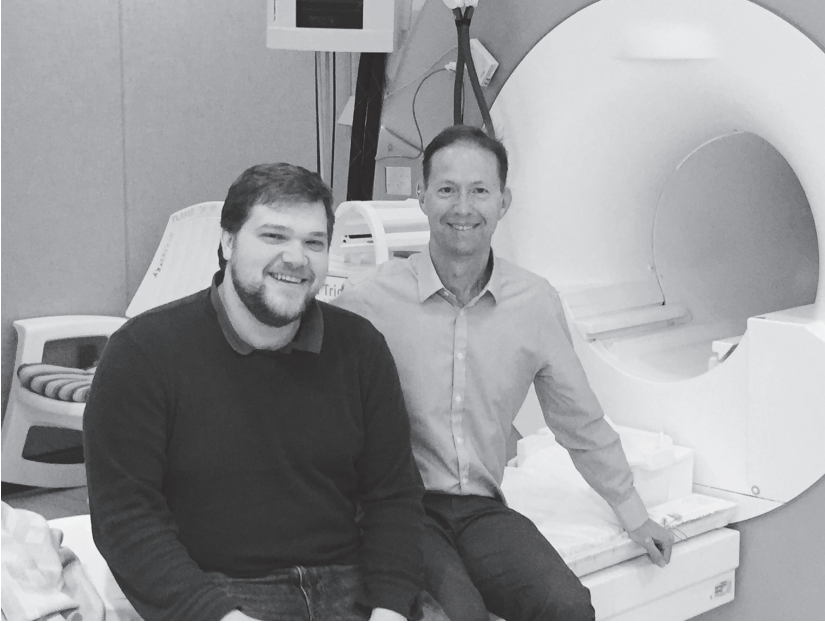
A photo of Tim Laumann (*left*) and me (*right*), just after I emerged from about six hours of MRI scanning at Washington University. Photo courtesy of Tim Laumann.
